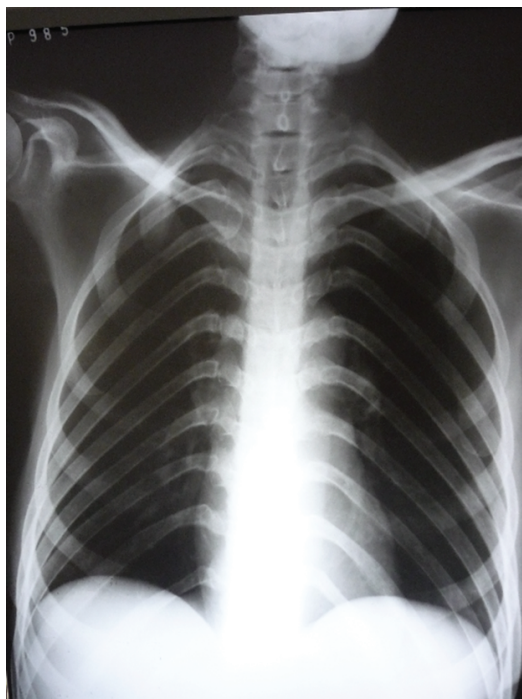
Chest X-ray of a patient with AIDS/pulmonary cryptosporidiosis, showing normal radiological findings. Source: Image database of the researcher.
